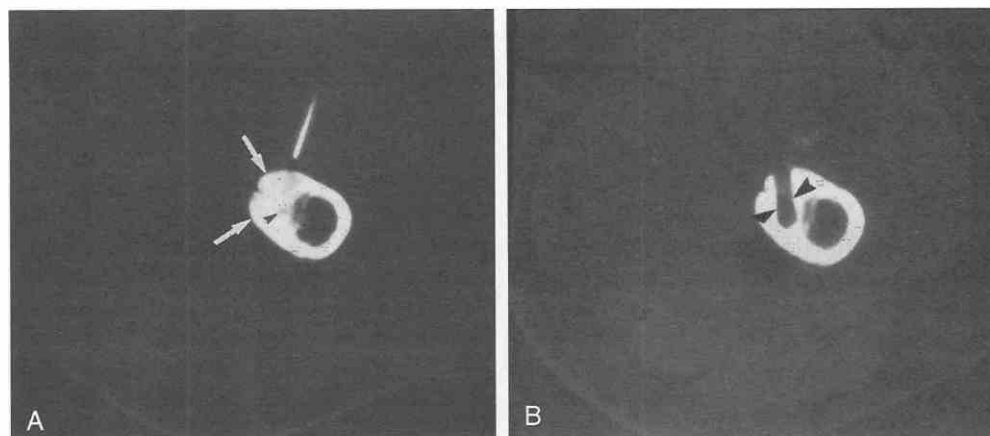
The patient is a 22-year-old man who underwent percutaneous removal of a proximal femur cortical osteoid osteoma under general anesthesia. CT scan shows initial localizing needle placement (A) directed toward the low-attenuation nidus (arrowhead). Marked reactive cortical thickening is present (arrows). Craig needle apparatus was then used to remove a core of bone, including the nidus. The core tract (B) is seen (arrowheads) with removal of the low-attenuation nidus. The patient was discharged from the hospital within 23 hours of this procedure.
